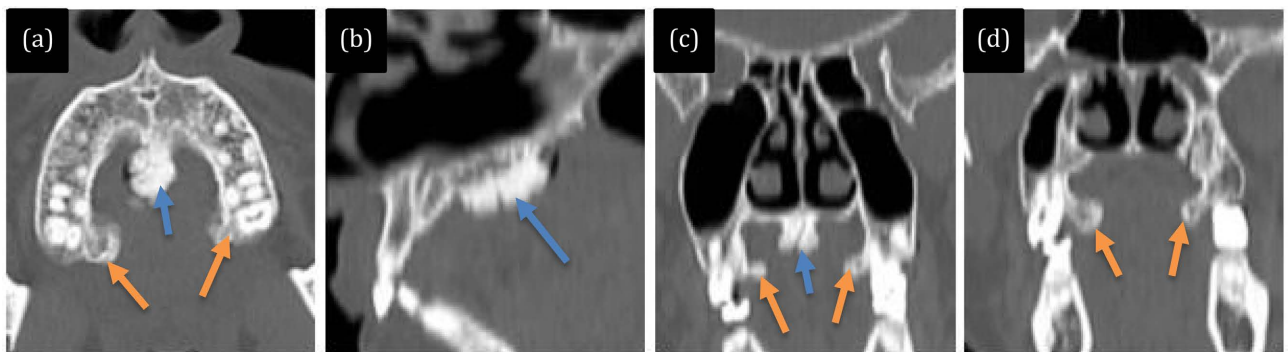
Computed tomography scan of a palatal torus associated with bilateral palatal exostosis. (a) axial section. (b) sagittal reconstruction. (c) and (d) coronal reconstructions. Palatal torus (blue arrow); bilateral palatal exostosis (orange arrow).
